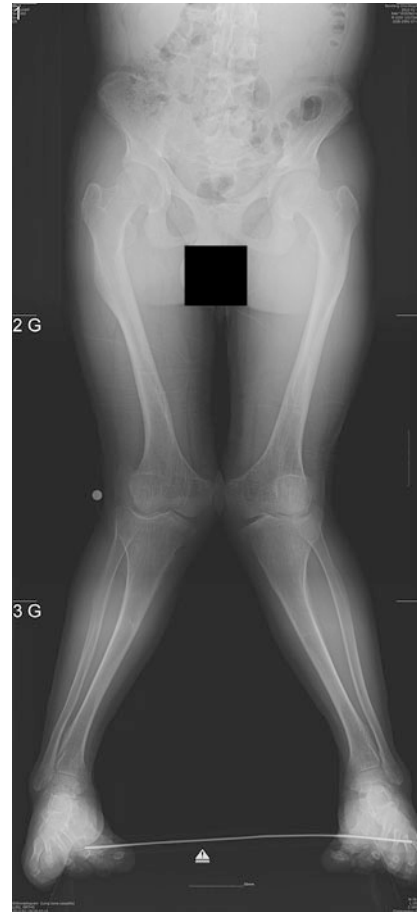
Bipedal full-length standing X-ray shows his both lower extremities with varus deformity of proximal femurs (LPFA $100^\circ/108^\circ$), valgus deformity of distal femurs (LDFA $77^\circ/78^\circ$), valgus deformity of proximal tibiae (MPTA $94^\circ/97^\circ$), and varus deformity of distal tibia (LDTA $97^\circ/96^\circ$)
